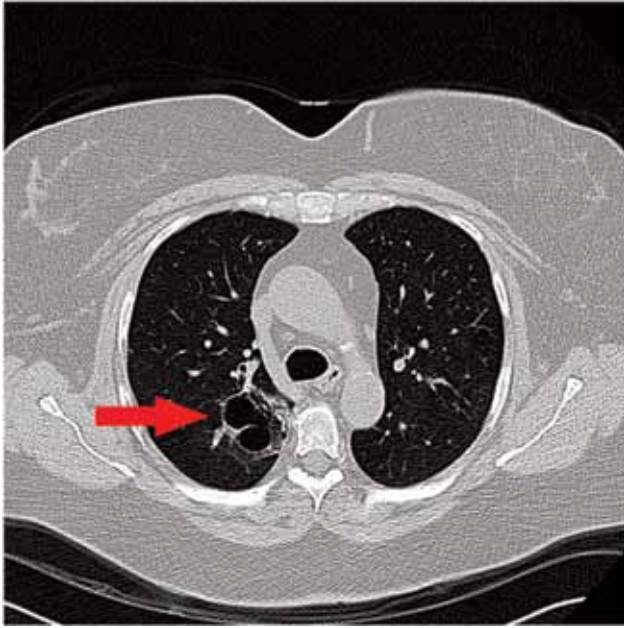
A CT scan of the chest five weeks after presentation shows that the right upper lobe mass has decreased in size to 4 cm. It is thin-walled and primarily gas-filled, but with some residual fluid.
